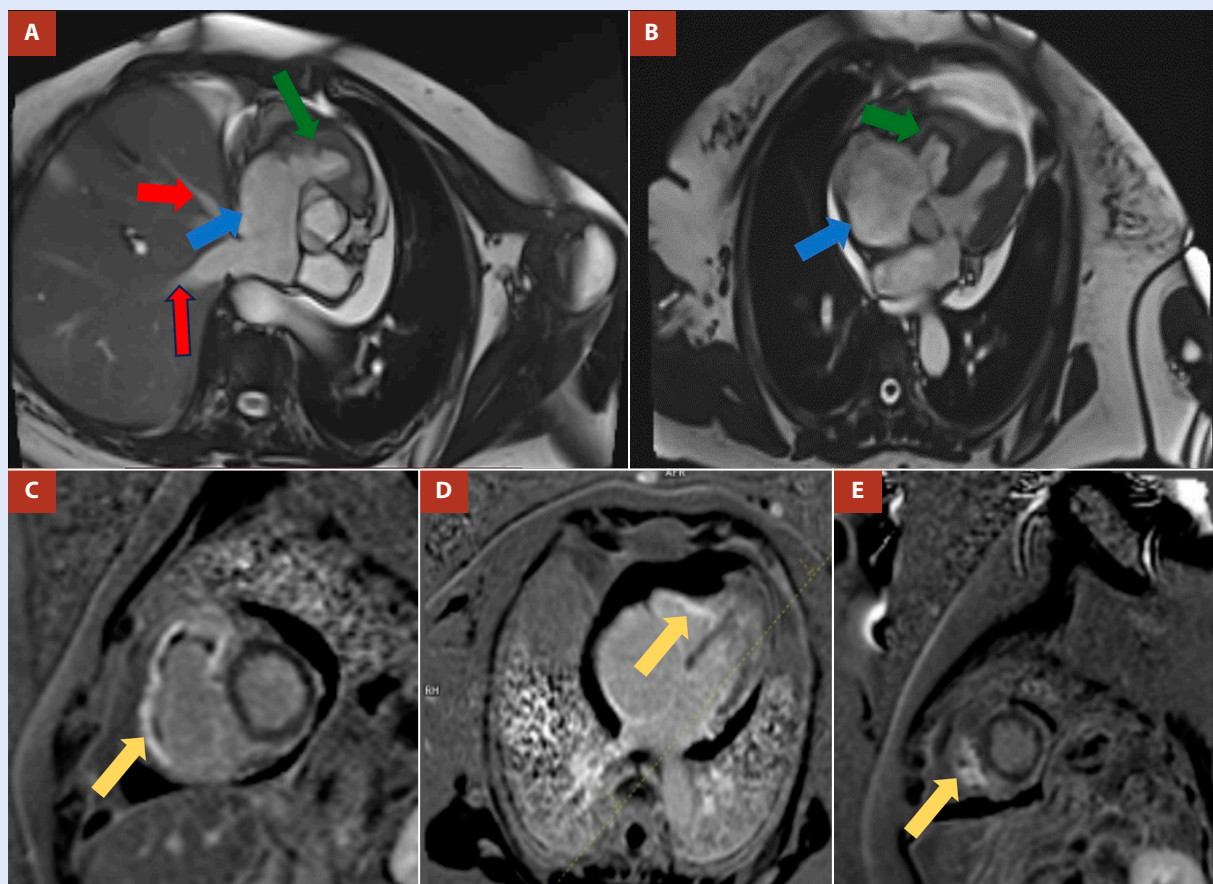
Cardiac magnetic resonance imaging. Dilation of the right atrium (blue arrow), obliteration of the right ventricle (green arrows), contrast reflux into the dilated hepatic veins (red arrows) due to increased systemic venous pressures, subendocardial enhancement in the mid and apical regions of the right ventricle representing areas of fibrosis (yellow arrows).
